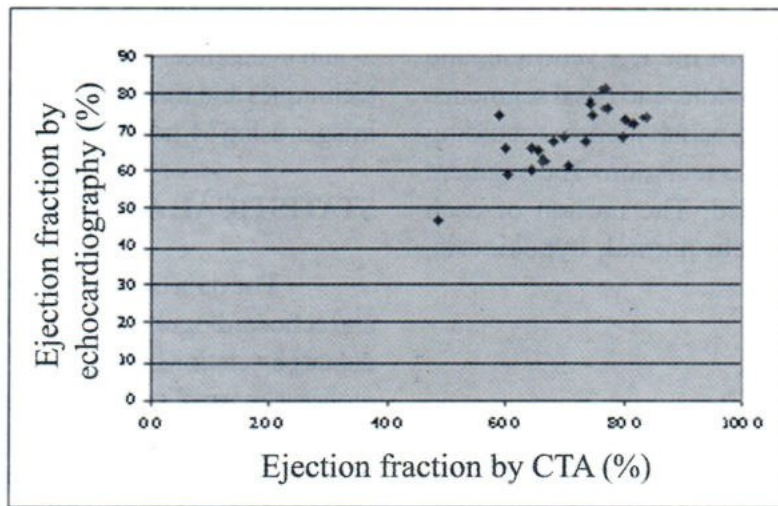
Left ventricular ejection fraction from CTA and echocardiography
